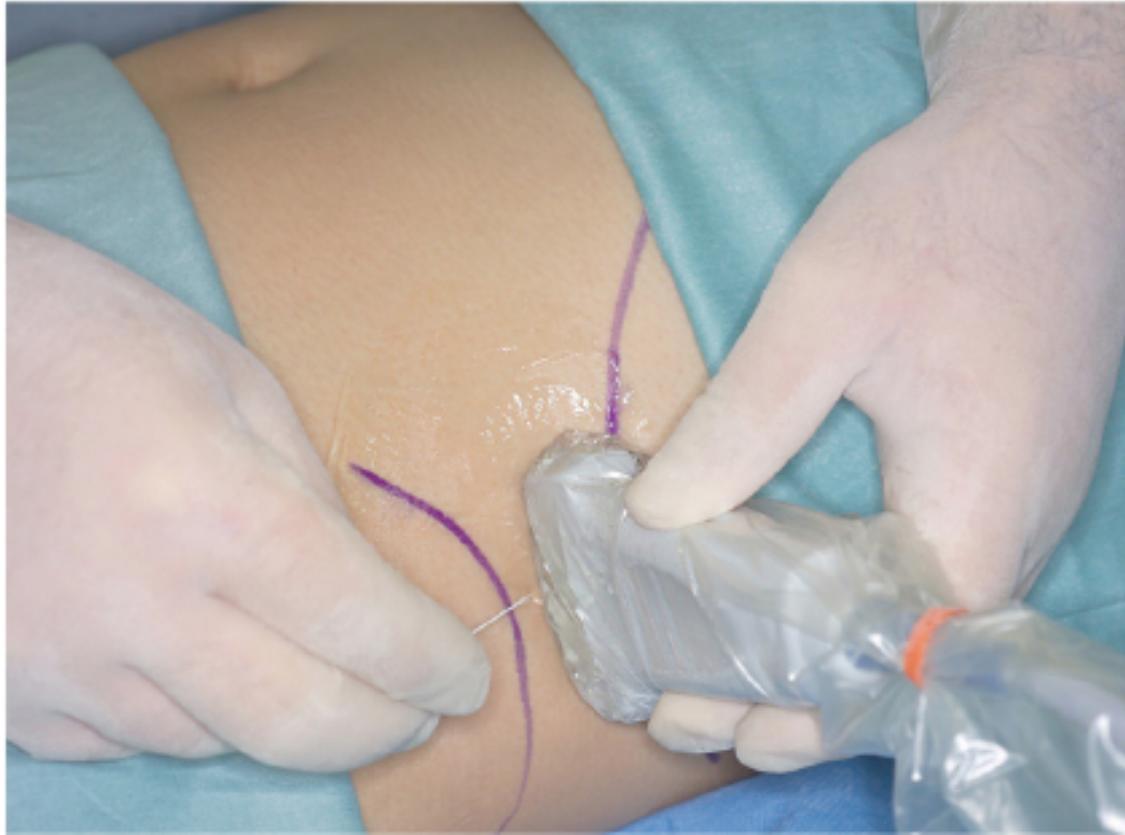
Transducer and needle positioning in ultrasound-guided transabdominal plane block.
